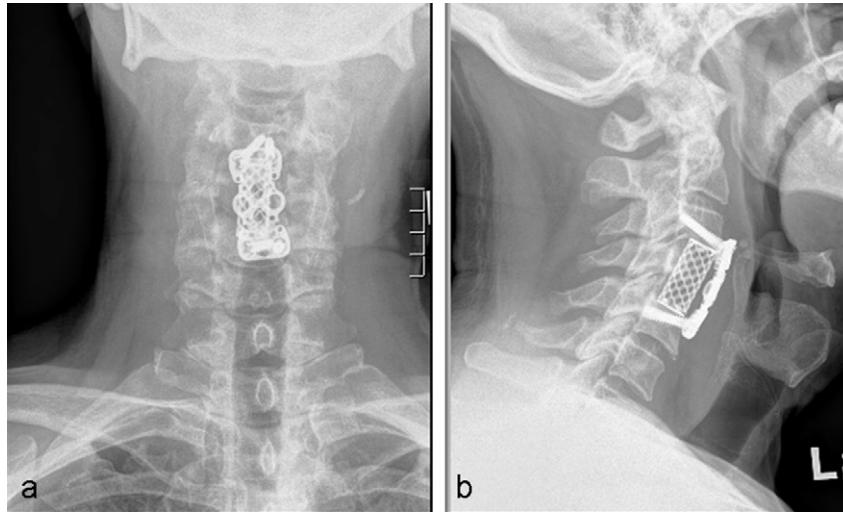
(a–b): The patient was operated via a ventral cervical approach for a C4 corpectomy and fusion with mesh cage and anterior cervical plating. Post-operative anterior–posterior (3a) and lateral (3b) X-rays demonstrate hardware position and alignment of the spine.
